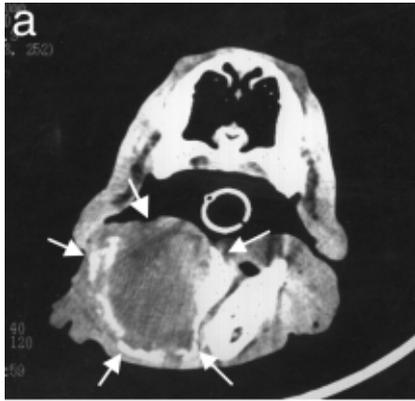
a: Computed tomographic soft tissue window image of patient 19. An expansile mass can be seen in the region of the caudal right mandible (arrows). Soft tissue margins are indistinct. Diagnosis: osteosarcoma.
